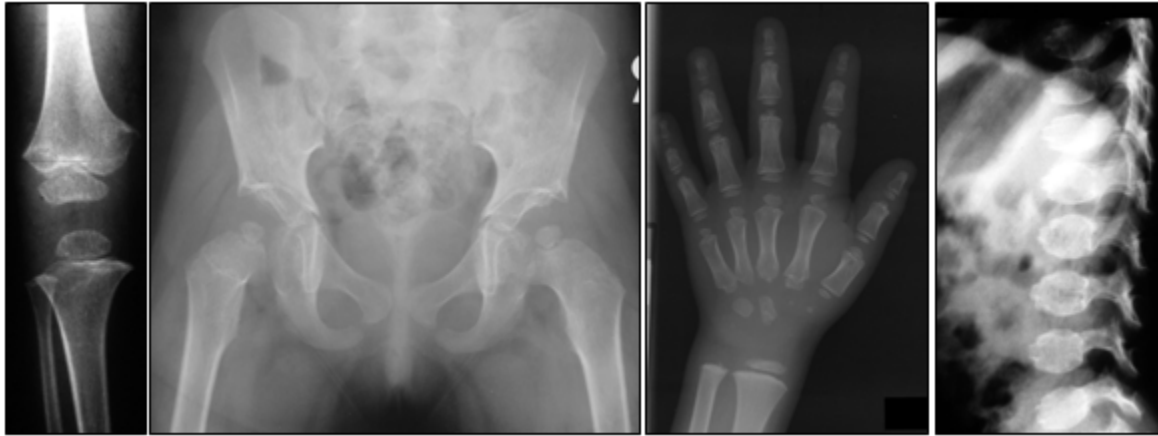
Radiographs of a prepubertal child showing the changes typical of pseudoachondroplasia
